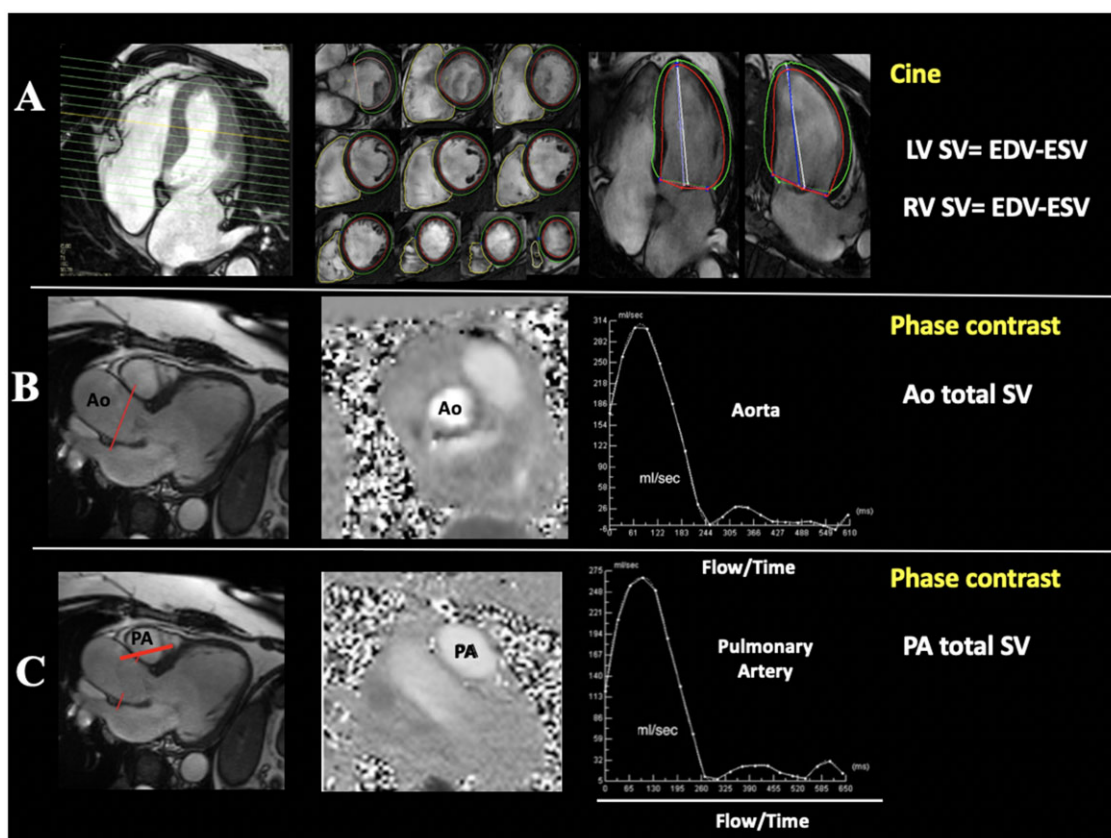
Methods of quantification of valvular regurgitation by cardiac magnetic resonance imaging (CMR). A: evaluation of left ventricular (LV) and right ventricular (RV) stroke volume (SV) using cine CMR acquisitions. LV and RV endocardial contours are traced in systole and diastole from a short-axis stack from base to apex; Aortic (Ao) (B) and pulmonary (PA) (C) flow assessed using phase-contrast sequence and the analysis of the flow time plot.
